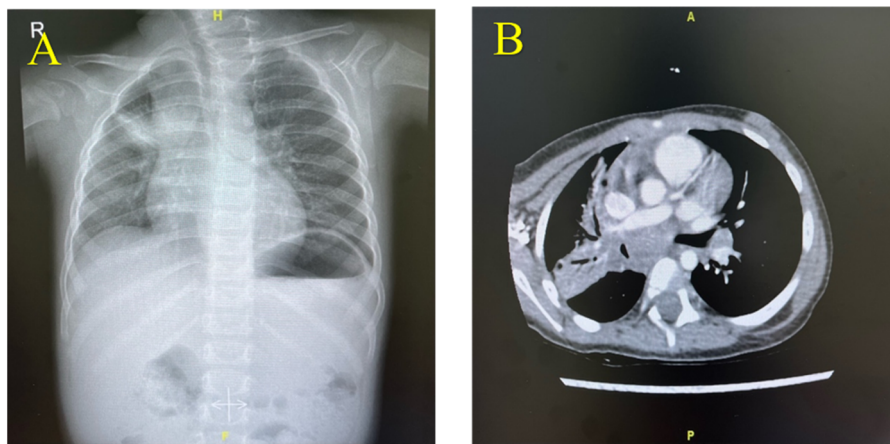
A: Chest X-ray PA view showing right upper zone opacity and widened mediastinum, findings that are commonly associated with pulmonary TB. B: Axial chest CT with IV-Contrast showing multiple matted, hypo-dense enlarged mediastinal lymph nodes, along with consolidation in the right upper lobe. These features are indicative of pulmonary TB, which often presents with mediastinal lymphadenopathy and parenchymal consolidation, particularly in the upper lung fields.
